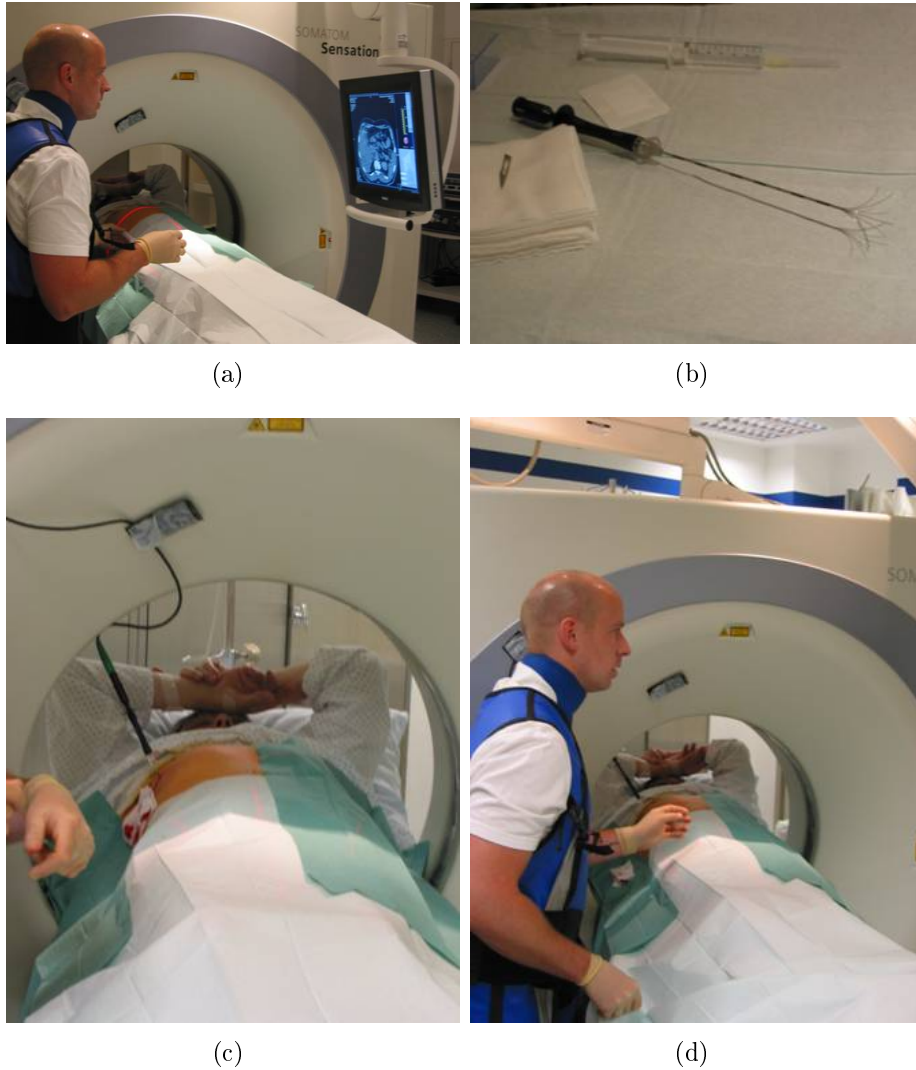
Intervention setup (CT-fluoro guided): (a) Interventional radiologist, CT-fluoro image display and patient lying on the CT table. (b) Needle after extension (RITA Medical Systems). (c) During RF ablation. (d) CT-fluoro acquisitions (with foot pedal).
